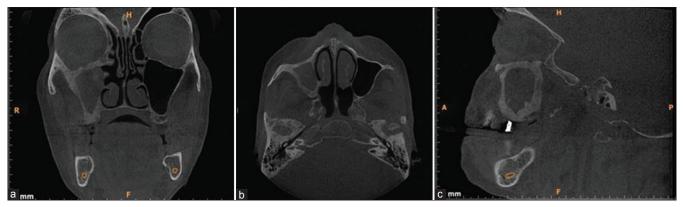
Cone-beam computed tomography scan showing opacification in maxillary sinus. (a) Coronal section (b) axial section (c) sagittal section
